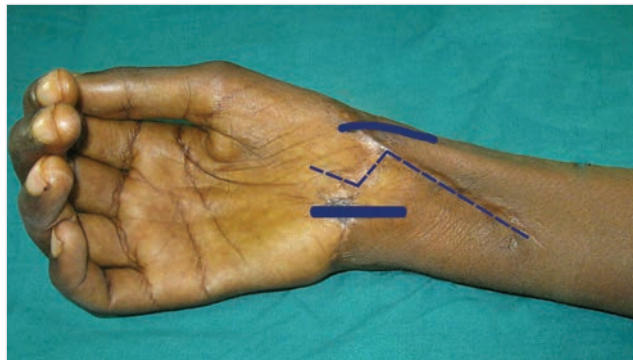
The solid line shows the line of the radial and ulnar arteries as mapped by Doppler. The dotted line is the proposed line of incision.
